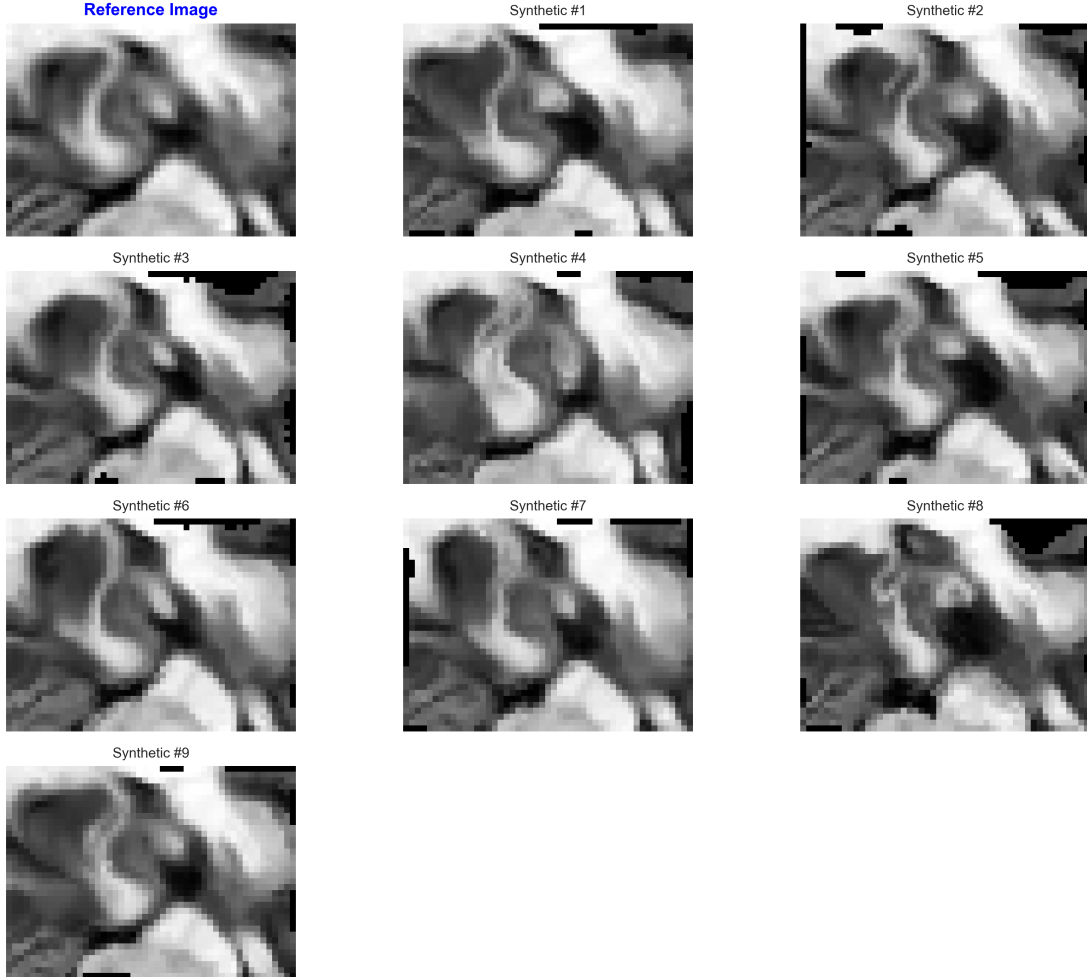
Proof-of-concept results for synthetic brain MRI generation. Top Row: Real patient MRI scans from the training population. Bottom Row: Synthetic patients generated by sampling the learned deformation latent space. The system successfully captures ventricle shapes and cortical structures while introducing novel anatomical variations.
